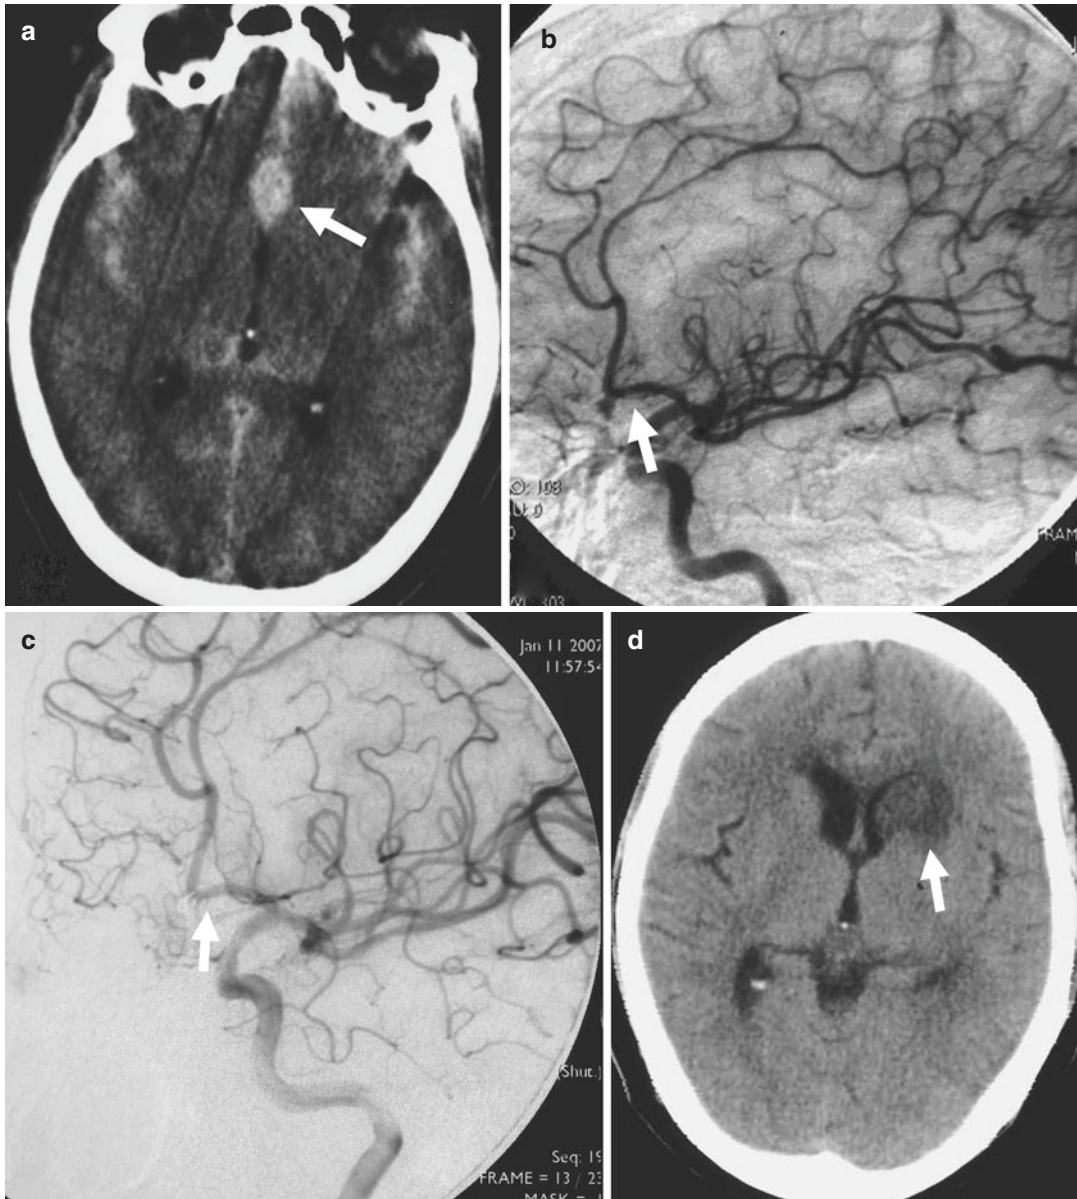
A 44-year-old woman. (a) Cranial CT scanning showing subarachnoid hemorrhage from an anterior communicating artery complex aneurysm. (b) Oblique view of the left internal carotid artery angiogram showing a left dominant filling of the anterior communicating artery complex and aneurysm. Noting the Heubner's artery arising from the aneurysm neck (arrow). (c) Working angle
